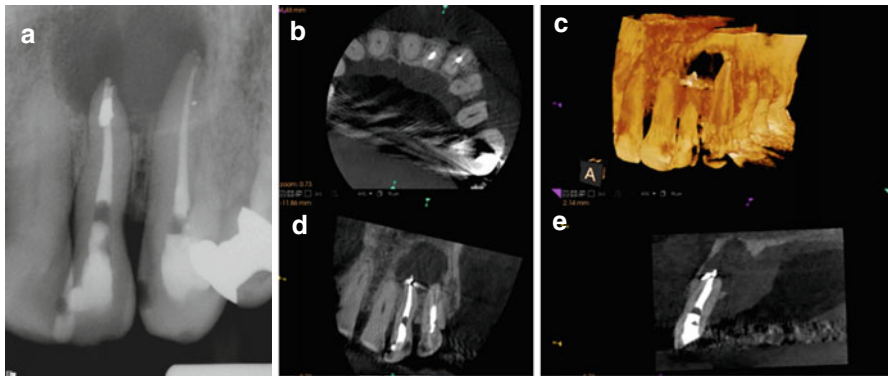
Periapical radiograph of teeth # 10 and #11 (a). The 2D radiograph does not allow for appreciation of the true size and extent of the defect. CBCT scan demonstrating the actual size of the defect (b–e). Perforation and loss of palatal bone can be clearly seen in the sagittal view (e)
